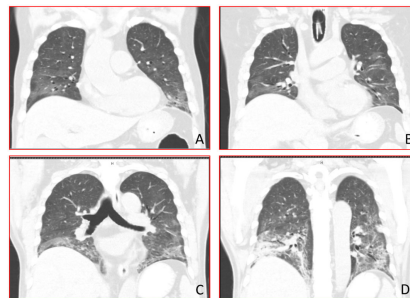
Show CT abnormalities of lung parenchyma during initial hospitalization. PJP and Nocardiosis were diagnosed by bronchoscopy. (A) and (B) show bilateral GGO occupying both basal lungs. (C) and (D) show reticular opacities with architectural distortion of both lower lung zones. Abbreviations. GGO; Ground-glass opacities, PJP; *Pneumocystis jiroveci* pneumonia.
